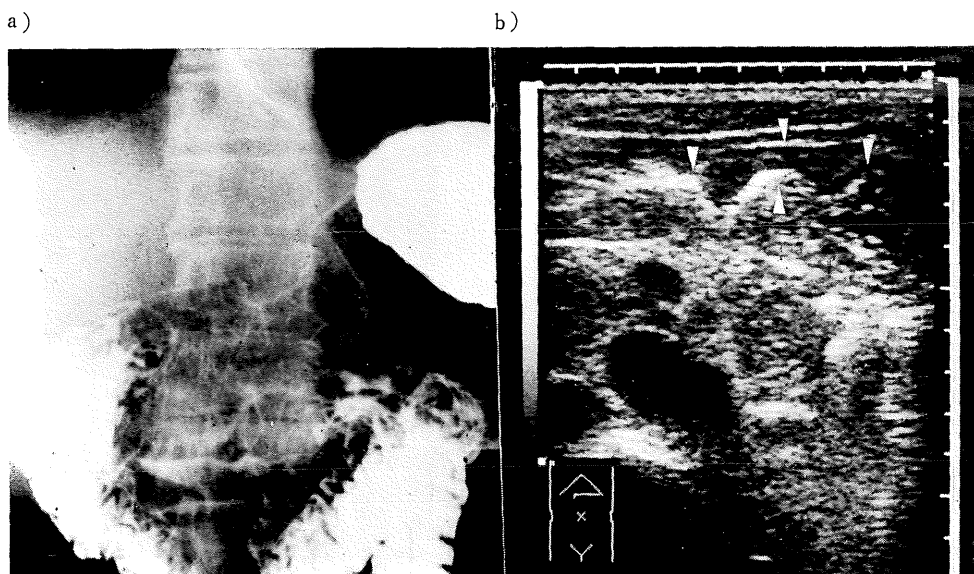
X-ray (a) and ultrasonography (b) of case 5.
